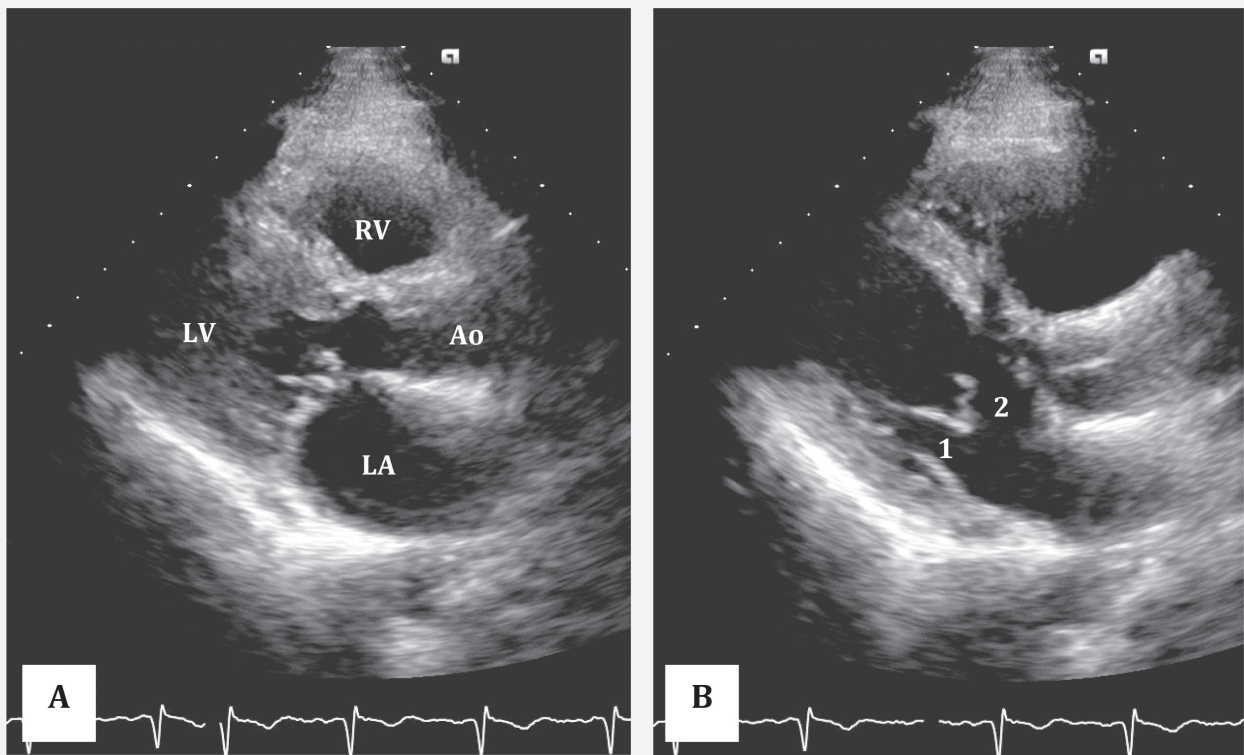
Transthoracic 2D echocardiography parasternal long-axis view of the mitral valve during systole (A) and diastole (B). Note the “seagull’s wing” configuration of the central portion of the mitral valve during diastole, separating orifices 1 and 2. Abbreviations: 2D, two-dimensional; Ao, aorta; LA, left atrium; LV, left ventricle; RV, right ventricle.
